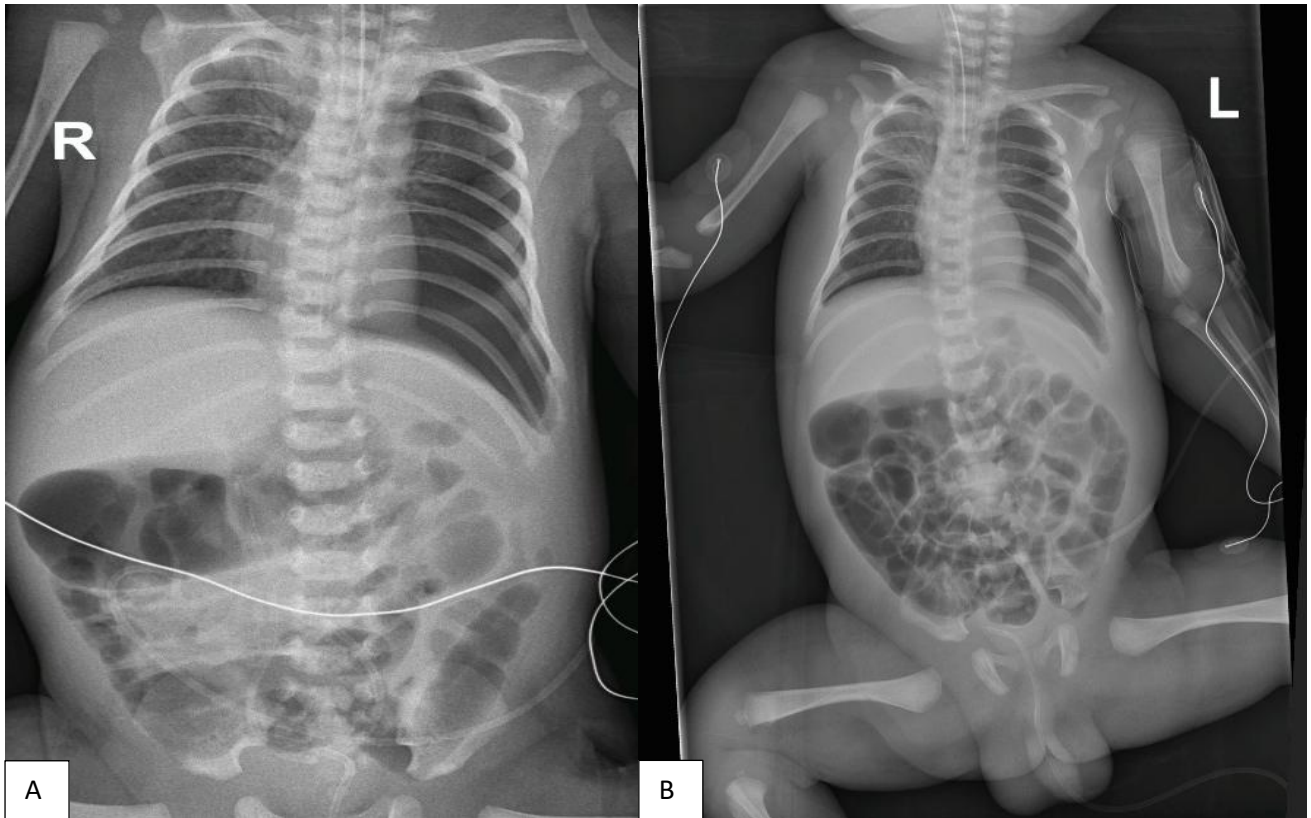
(A and B): Post-operative X-rays following the left CDH repair showing the left diaphragm intact and abdominal contents within the abdominal cavity.
